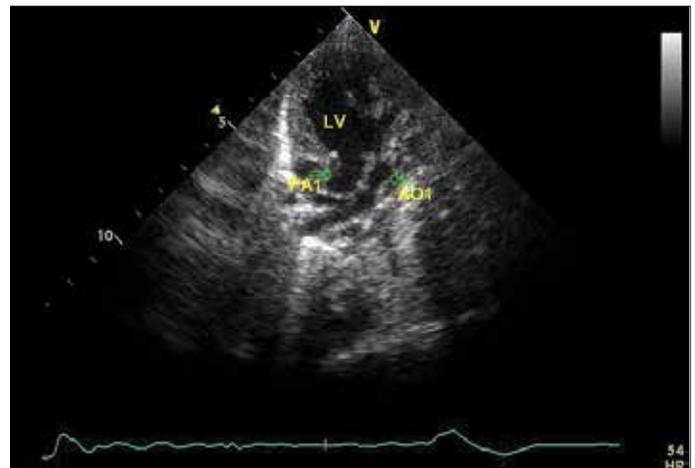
Echocardiogram showed aorta-1 and pulmonary artery-1 connecting the left ventricle
